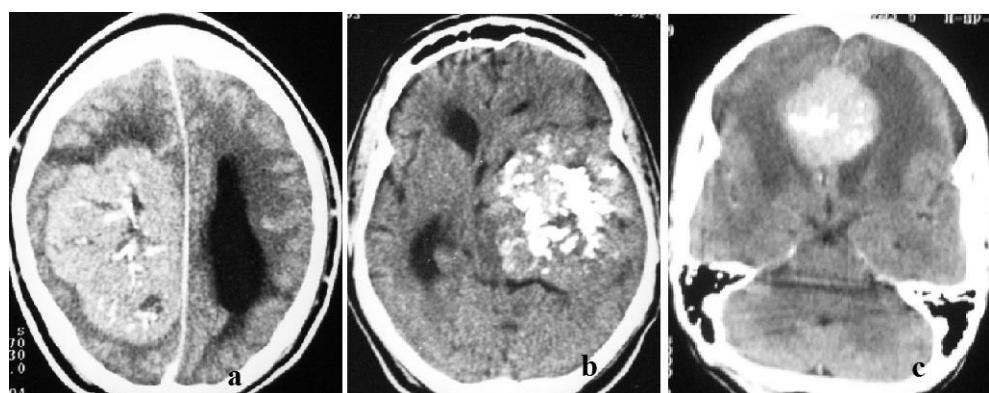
CT scan images in brain tumours. a. Intracranial meningioma in the right cerebral hemisphere close to the falx with well-defined margin and some calcifications. b. Glioma in the left temporal region with extensive calcification and compression of ipsilateral ventricle. c. Well-defined round midline aneurysmal mass in the frontal lobe showing intense contrast enhancement and marked surrounding oedema.
